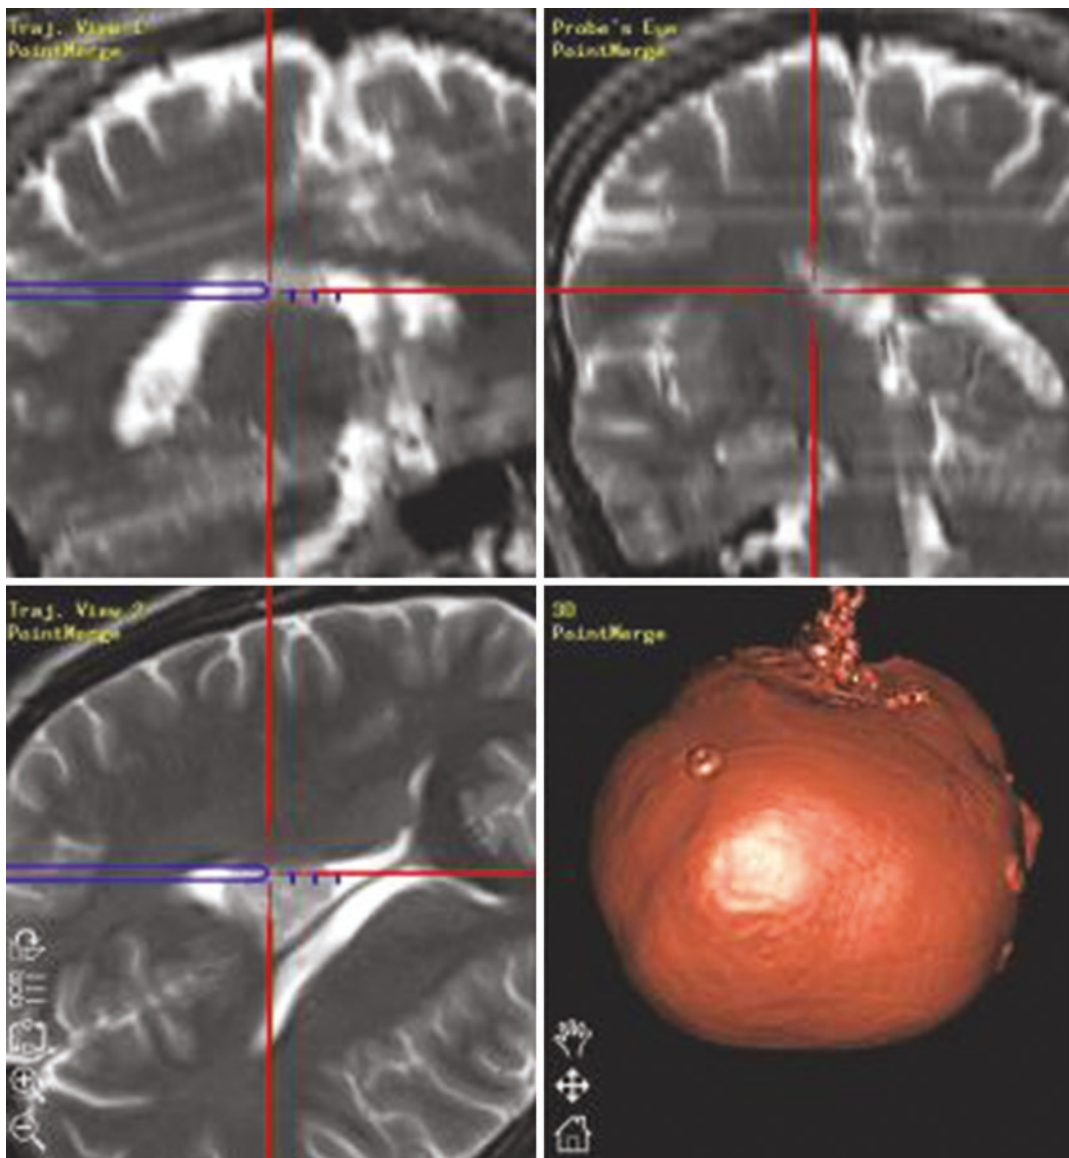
Neuronavigation system. MRI was merged with a CT scan, 3D reconstruction (bottom right) shows adhesive markers (fiducials)
